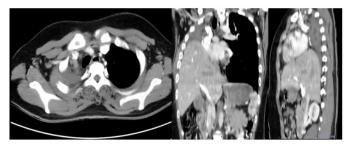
Follow up CT scan after pneumonectomy
